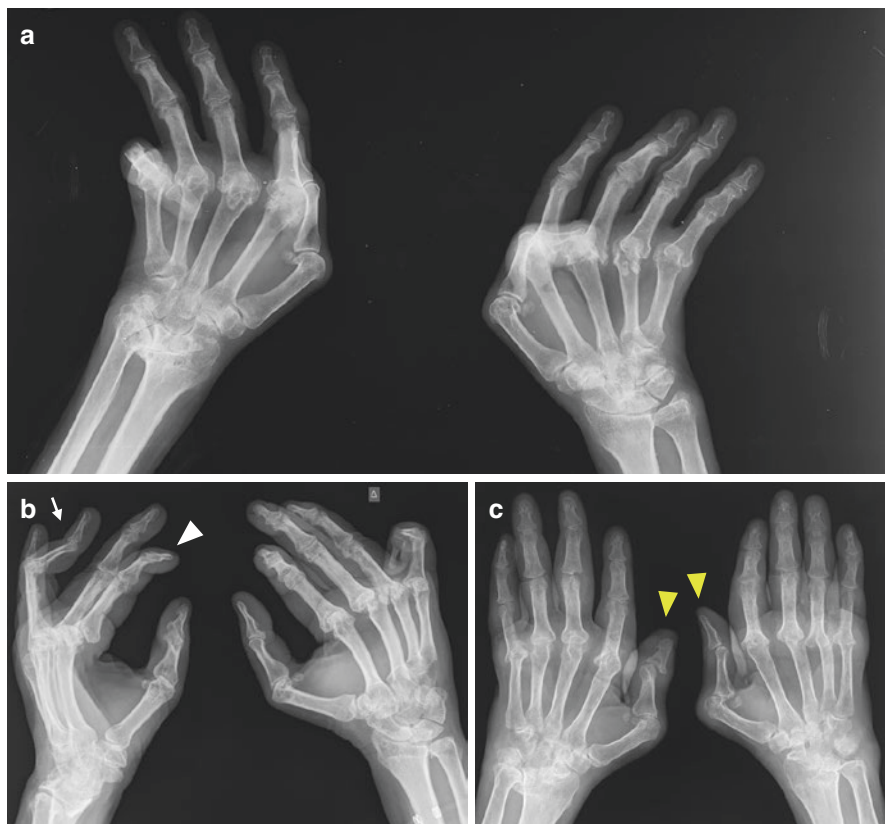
Various hand deformities on plain radiography
